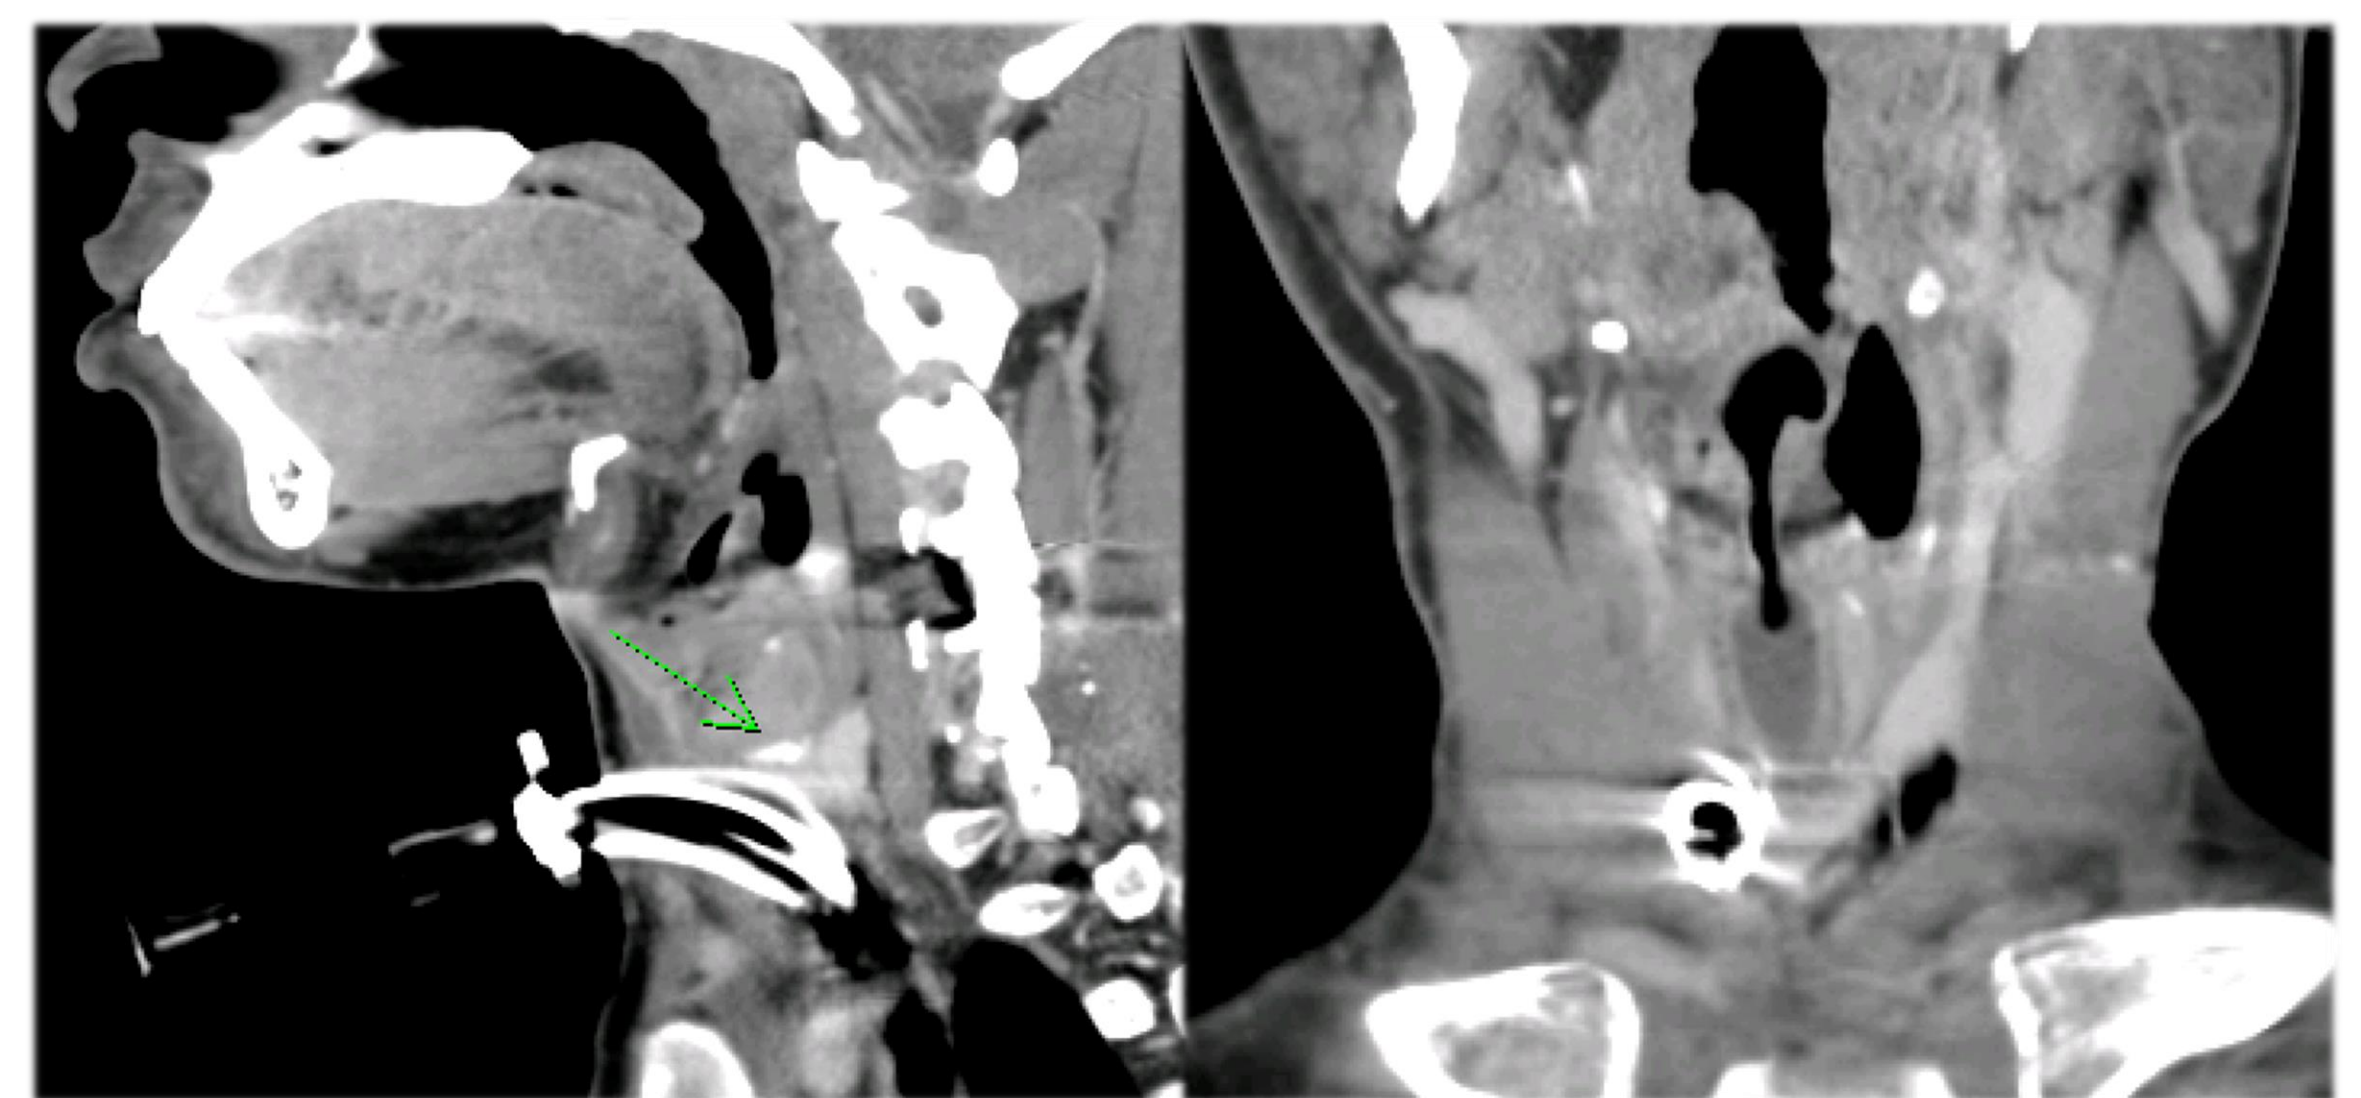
Sagittal and coronal CT with cartilaginous stenosis superior to the stoma
